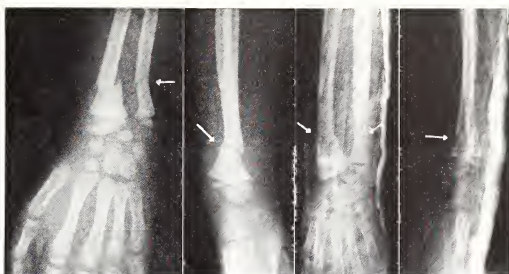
X-rays showing a common injury to the lower end of both bones (radius and ulna) of the forearm. These fractures are the result of an attempt to break a fall with an outstretched hand.
